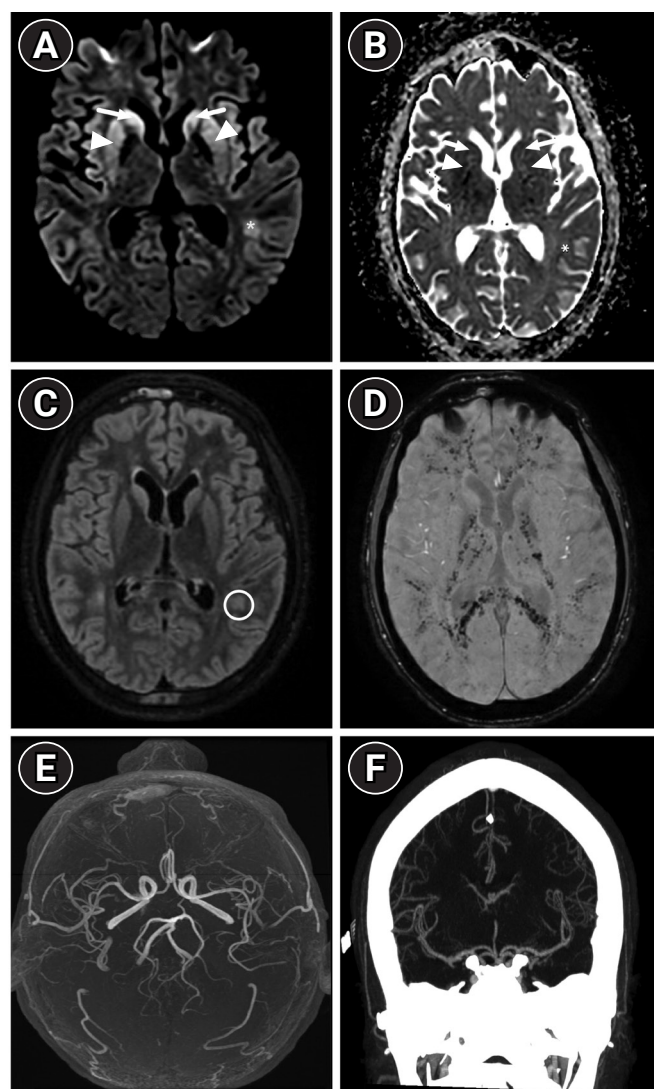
Second axial brain magnetic resonance imaging performed 26 days after admission. (A) Diffusion-weighted imaging and (B) the corresponding apparent diffusion coefficient map showing bilateral hyperintensity with restricted diffusion of the head of caudate (arrows) and putamen (arrowheads), and left occipital subcortical white matter (asterisks) suggesting additional hypoxic-ischemic encephalopathy. (C) Fluid-attenuated inversion recovery sequence showing hyperintensity of a left occipital white matter lesion (circle) without evidence of collateral flow. (D) The susceptibility-weighted Imaging sequence reveals widespread and consistent pinpoint susceptibilities within the gray matter, gray-white junction, posterior arms of the internal capsules, the splenium of the corpus callosum, basal ganglia, and thalami. This presentation is characteristic of the "walnut kernel microbleed pattern," which strongly indicates cerebral fat embolism. (E, F) The corresponding three-dimensional time-of-flight angiography and computed tomography angiography revealing no abnormalities of intracranial vessels.
